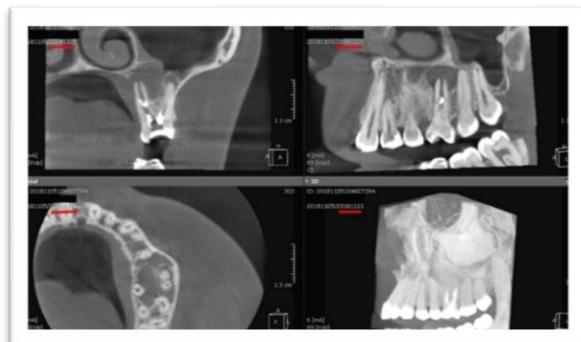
CBCT (maxillary cystic lesion and healing outcome)
